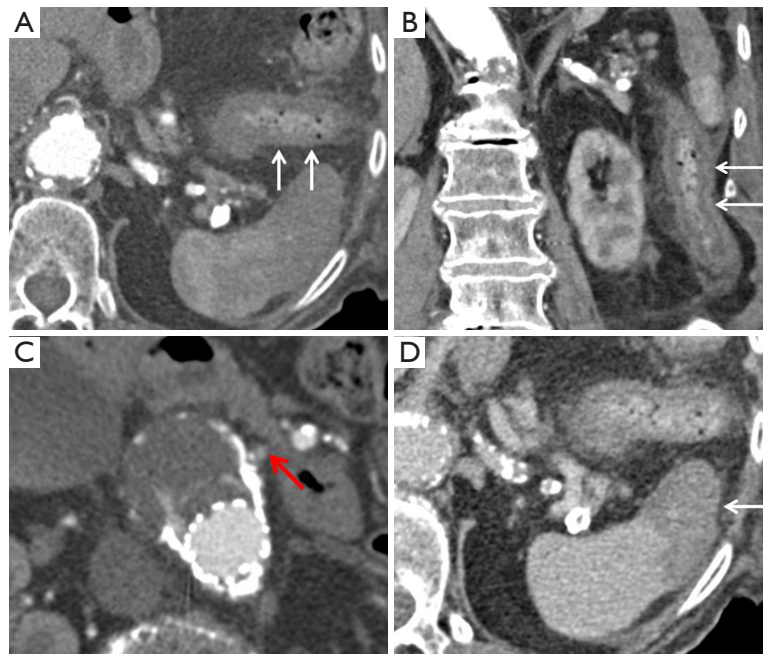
Bowel ischemia in a 90-year-old woman after endovascular infrarenal abdominal aortic repair for 6 days. (A) Axial and (B) coronal CT angiogram show circumferential wall thickening at descending colon with pericolic fat stranding (arrows); (C) the IMA was filled with contrast supplied by the endoleak (red arrow); (D) axial delayed contrast-enhanced CT reveals splenic infarction at anterior pole (arrow). IMA, inferior mesenteric artery.
